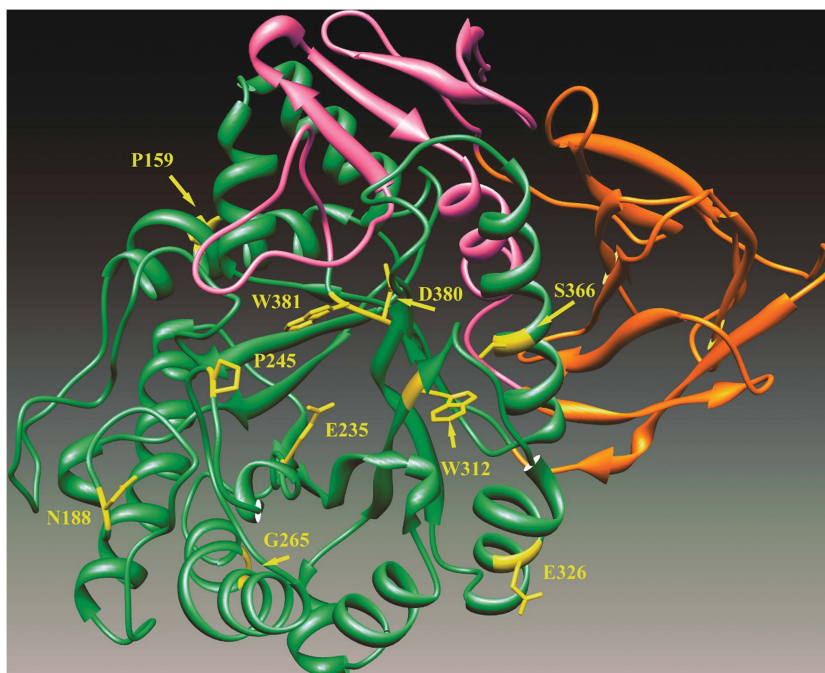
Location of GBA mutations on the X-ray structural model. Catalytic domain is represented in green while the N terminal and C terminal domains are drawn in orange and red, respectively. Positions of the mutations are indicated in yellow.
